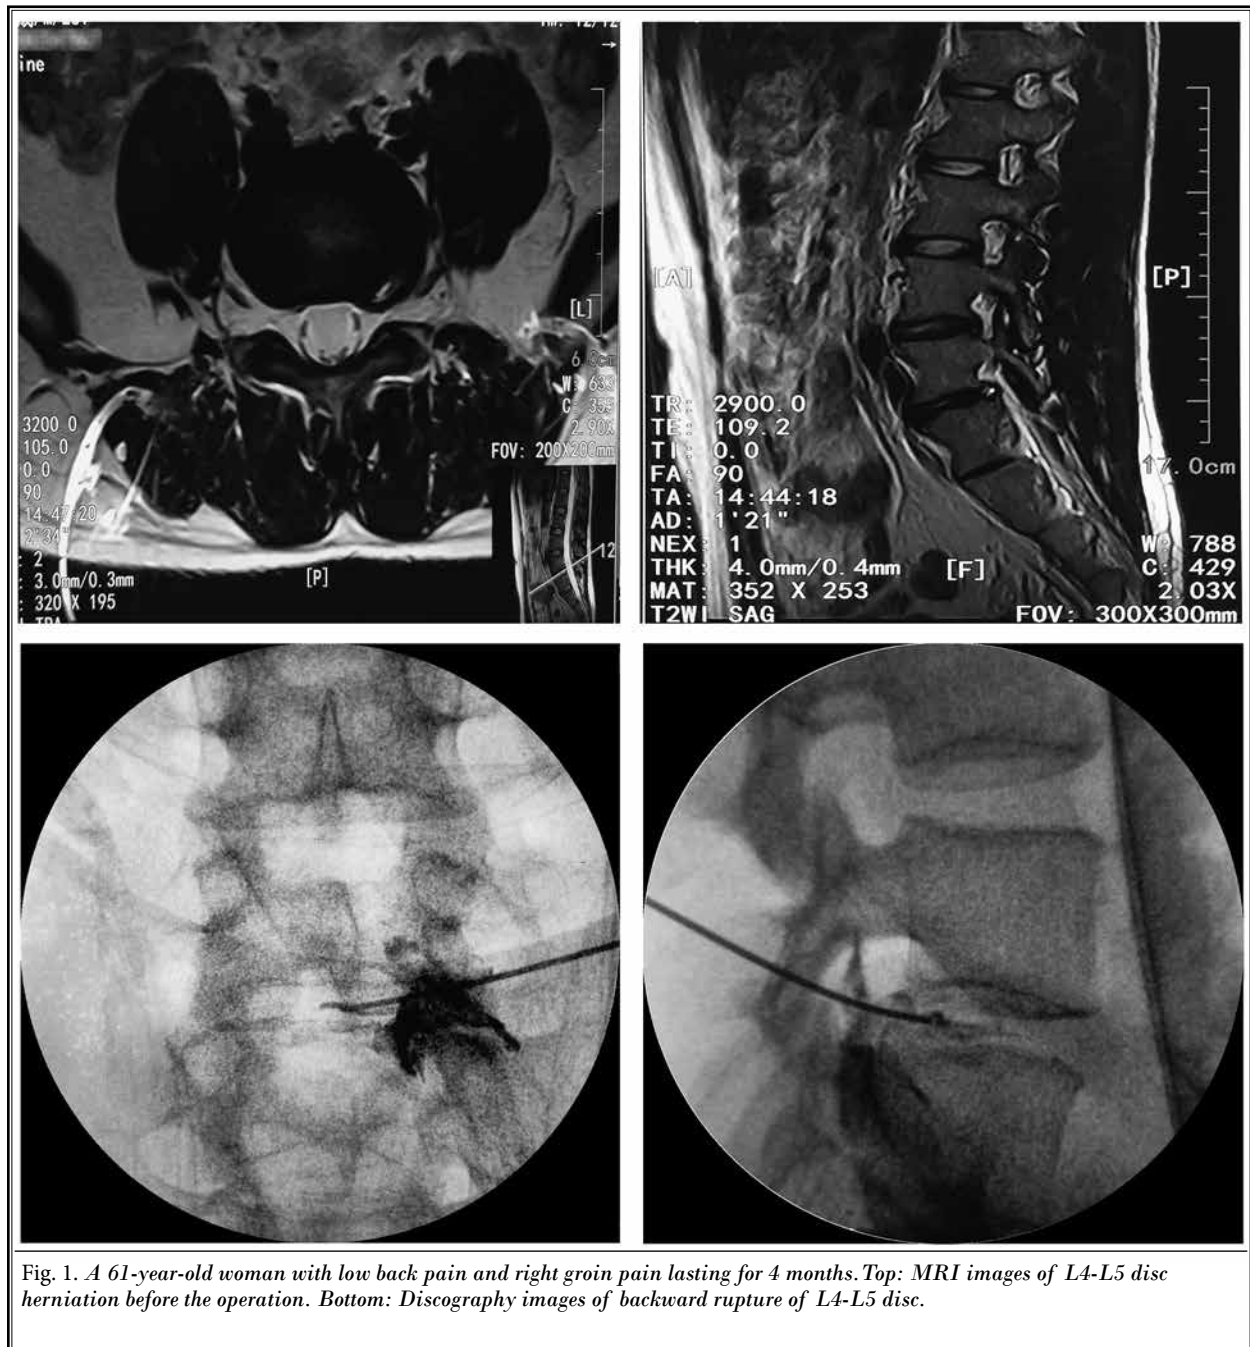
A 61-year-old woman with low back pain and right groin pain lasting for 4 months. Top: MRI images of L4-L5 disc herniation before the operation. Bottom: Discography images of backward rupture of L4-L5 disc.
